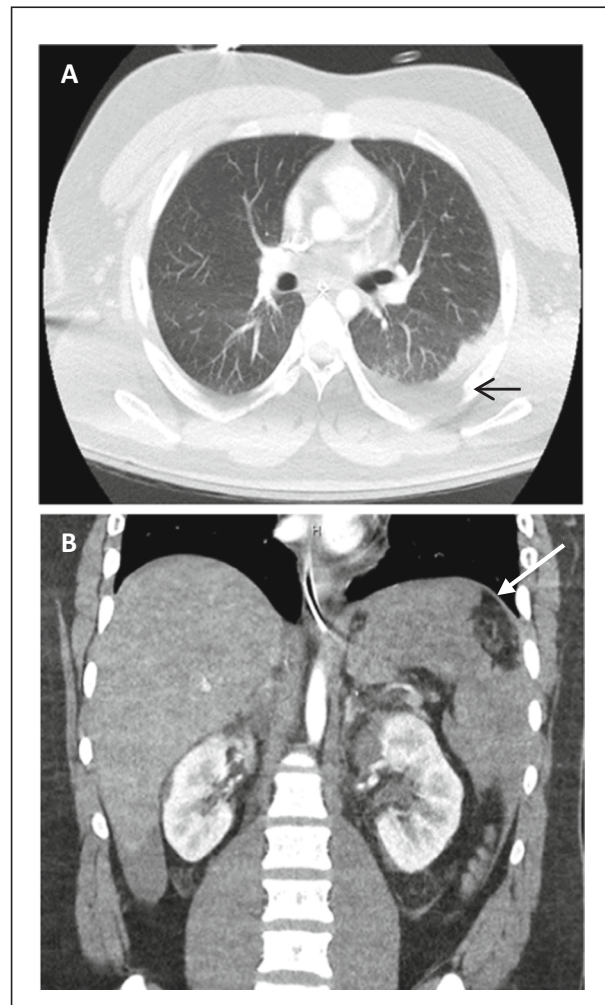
Initial computed tomography of the chest/abdomen with IV contrast. Note the pleural effusion consistent with hemothorax (black arrow). Note the splenic laceration (white arrow).
